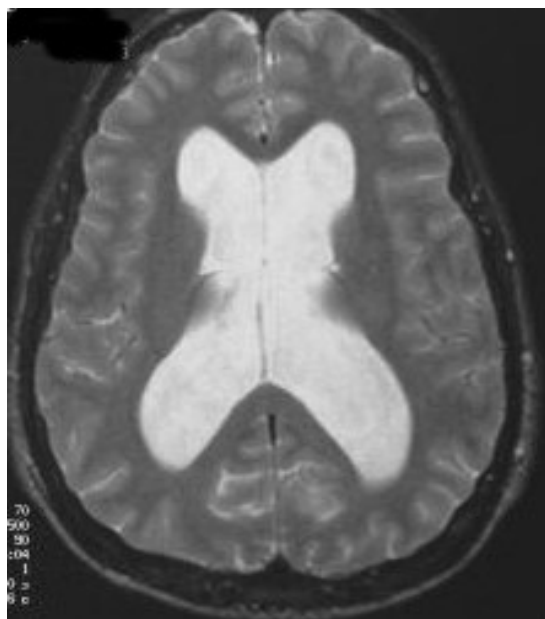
MRI exam – hydrocephaly appearance
